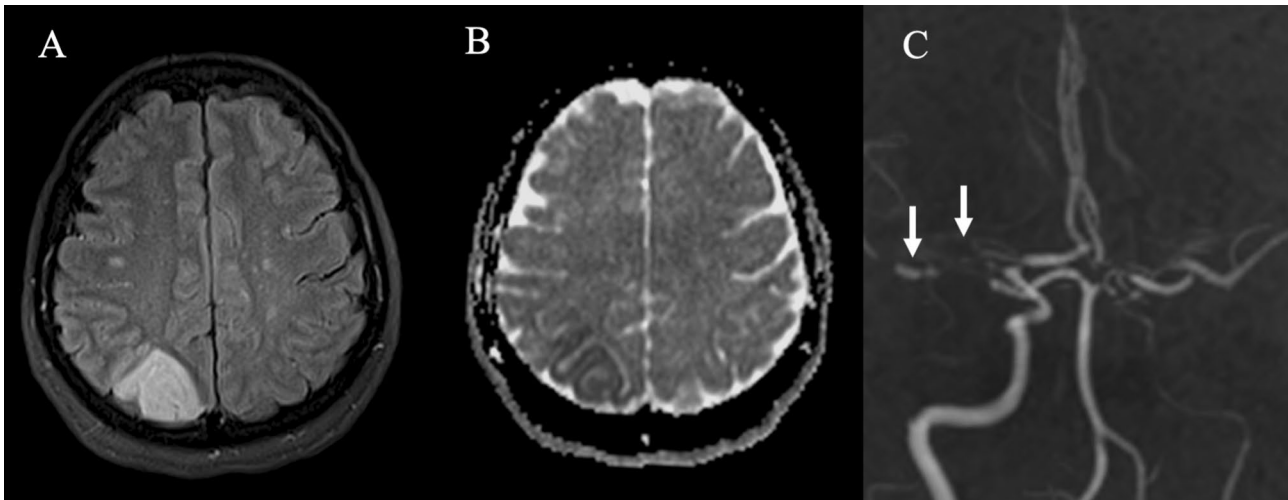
Axial fat-suppressed FLAIR (a), Apparent Diffusion Coefficient (b) and coronal reformat of 3D maximum intensity projection MR Angiography (c) show an acute ischemic area in the right parietal region hyperintense in FLAIR (A) with low Apparent Diffusion
